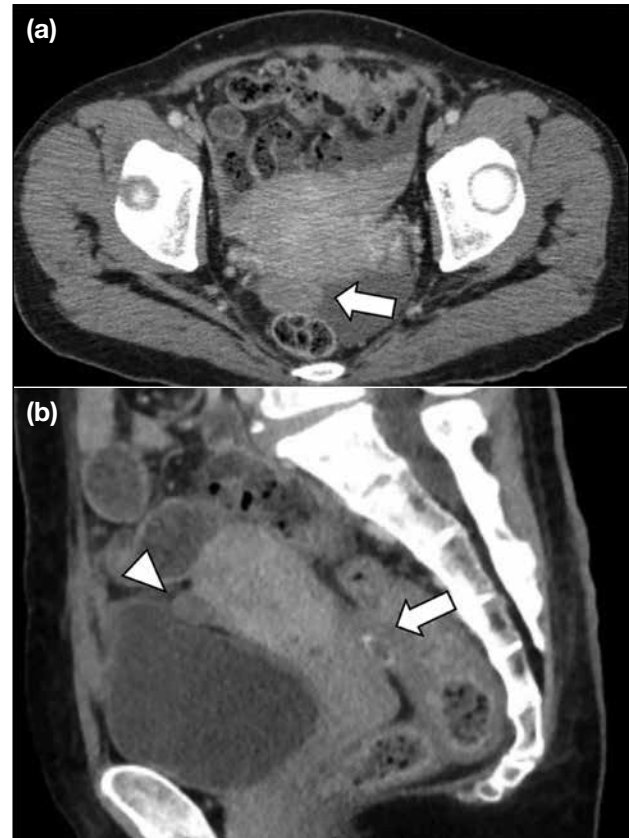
Contrast computed tomography images demonstrating peritoneal disease at the pelvis, with (a) showing deposits at the pouch of Douglas (arrow). (b) This image allows better appreciation of deposits at the peritoneal surface of the urinary bladder (arrowhead) and pouch of Douglas (arrow).
